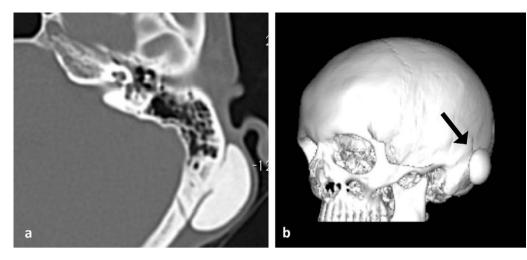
Non-contrast CT: axial (a) and 3D reconstruction (b) showing a pedunculated, superficial left mastoid osteoma.
